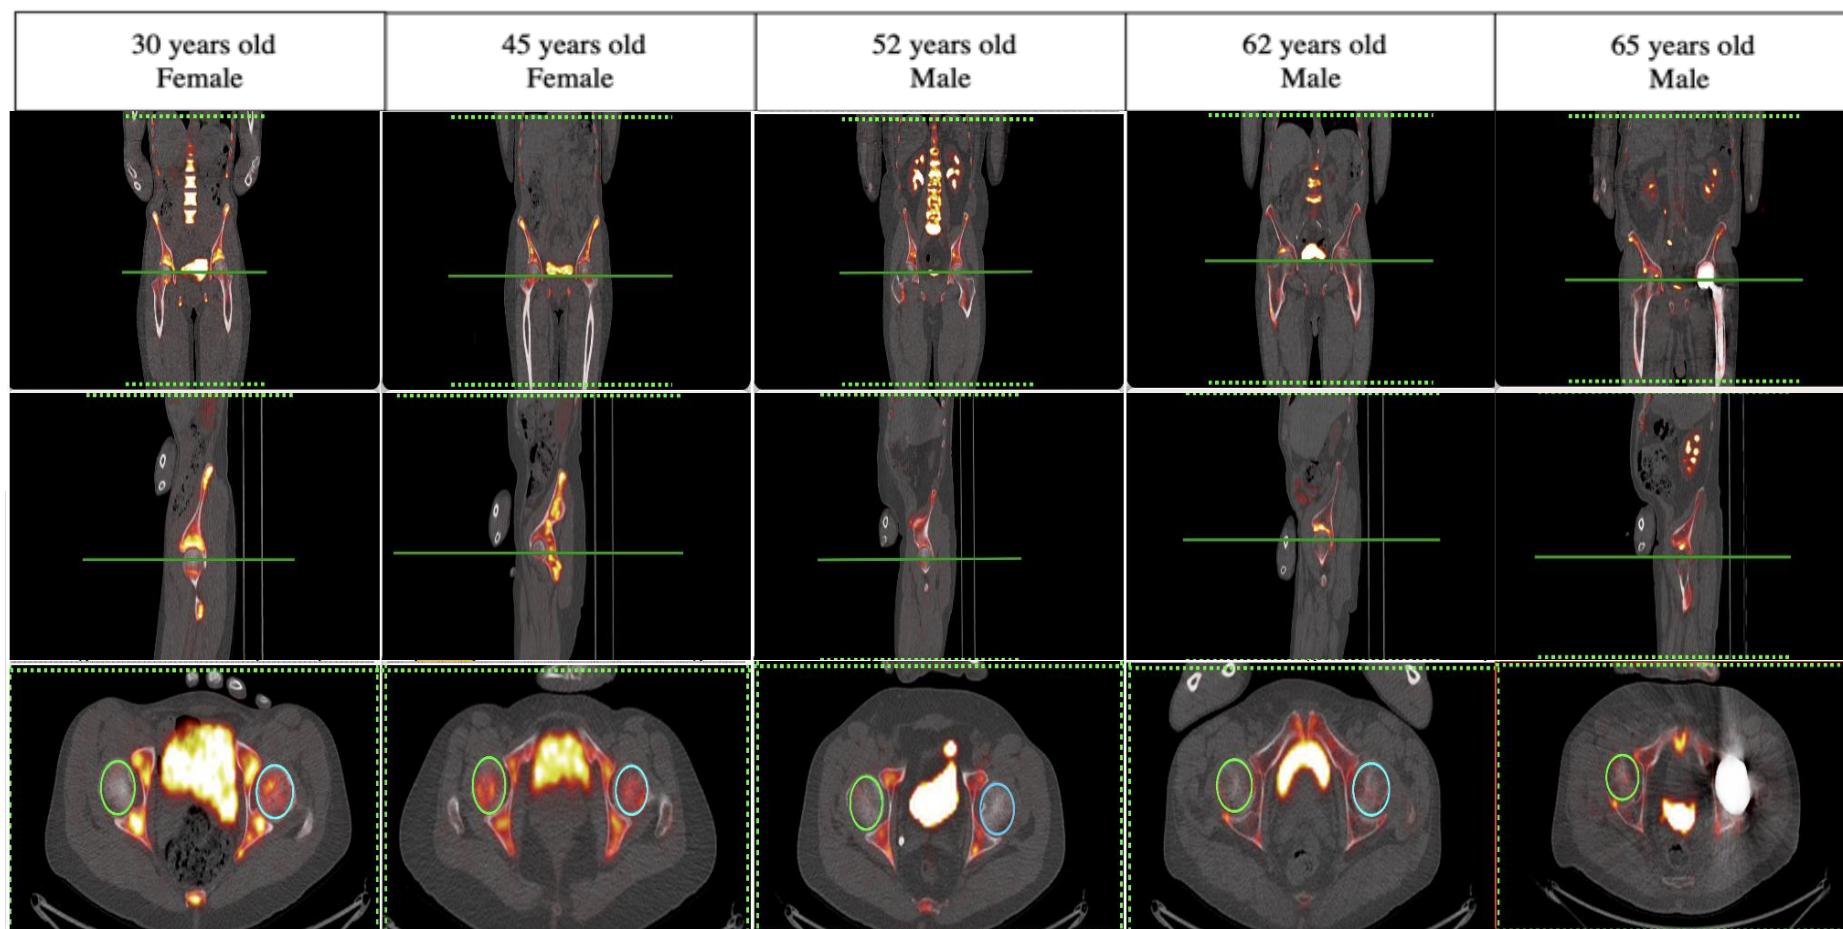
Coronal, sagittal, and axial fused ^{18}F -NaF PET/CT images for the hip region for AKU patients.
